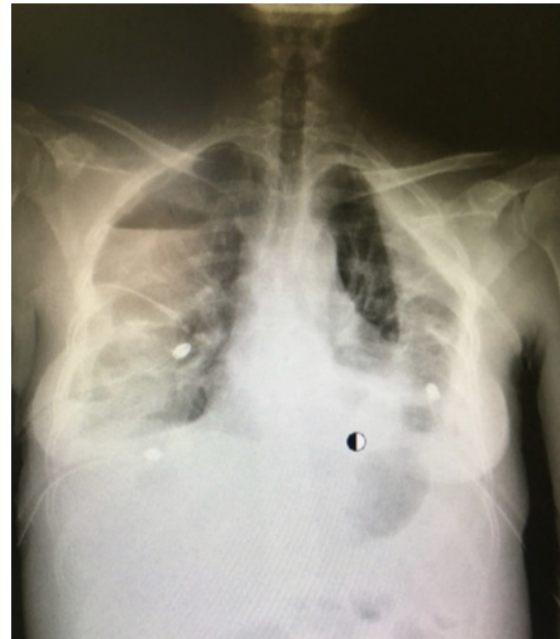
Chest radiography after insertion bilateral drainages.
